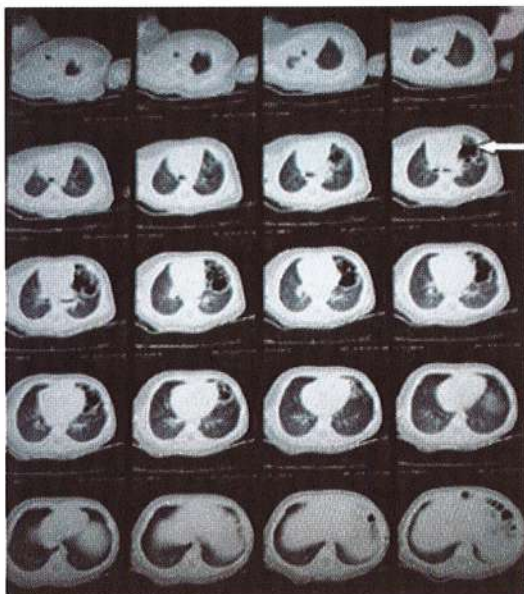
CT Scan- Cystic lesions in the lingular lobe
